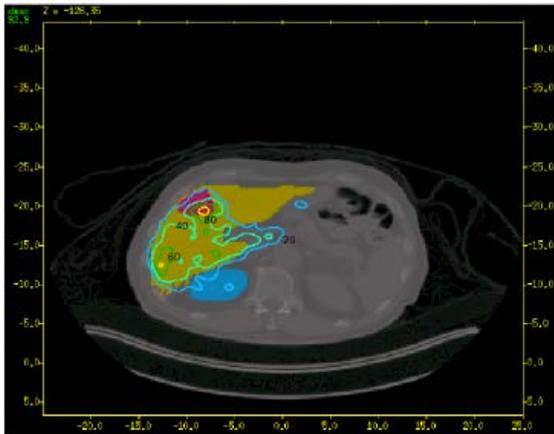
Reconstructed in-patient dose distribution superimposed on patient's axial CT data. The red, green and blue contours designate the tumor, liver and right kidney, respectively.
